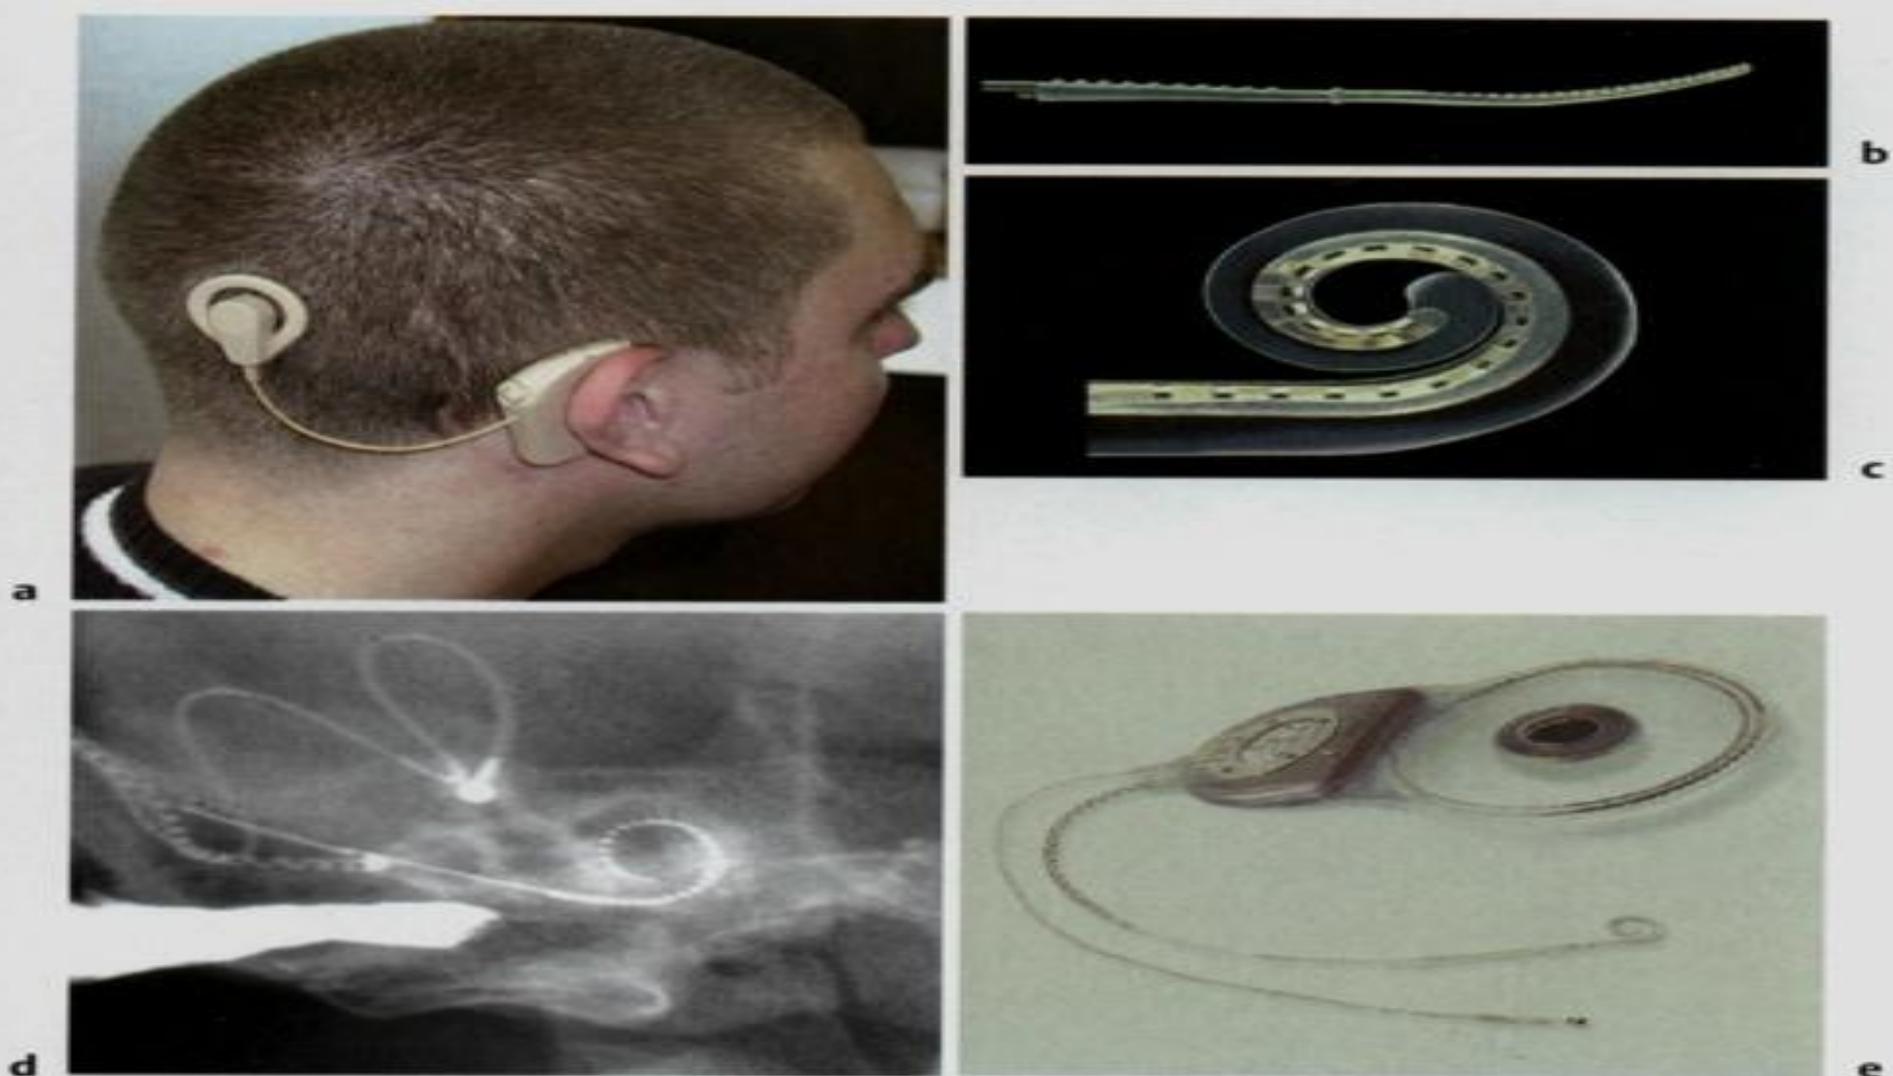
The cochlear implant has proved a great advance in the management of profound hearing loss in children and adults, where conventional aids are ineffective to restore hearing. An ear-level microphone is fitted like a hearing aid. Sound is converted to electric signals to a processor and transmitted to electrodes inserted into the cochlear (a). The nuclear contour electrode contains a stylette (b). When the stylette is removed, the coil forms a curl which conforms to the cochlear (c). The nuclear contour device contains 22 electro-terminals, which can be seen on the radiograph showing the implant in place in the inner ear (d). e This image shows the complete device with the electrode, reference electrodes, receiver core, and microchip packet.
